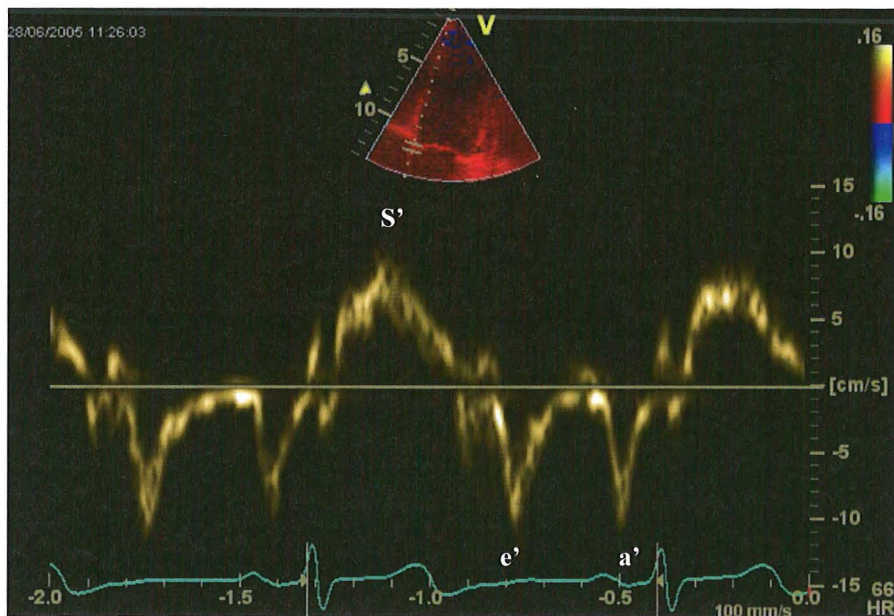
Mitral annular tissue Doppler curve in one of the preeclamptic women measured at the septal position of the mitral annulus. S' , peak systolic mitral annular velocity; e' , early diastolic mitral annular velocity; a' , late diastolic mitral annular velocity.
